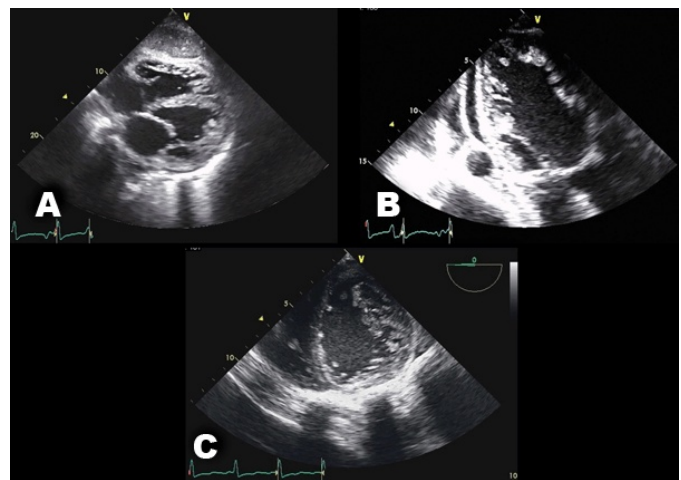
(A) Four chamber sub costal view showing hypertrabeculations, (B) Apical three chamber view showing hypertrabeculations, (C) Gastric short axis view of TEE showing hypertrabeculations.
